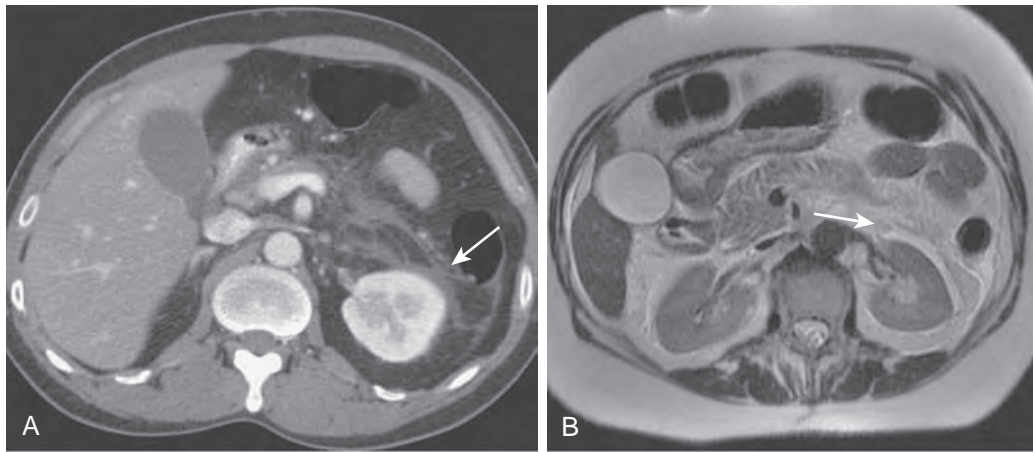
Inflammation of pancreatitis spreading from the pancreas to the left kidney by means of the splenorenal ligament: MRI and CT findings in the same patient. A. CT shows fluid inferior to the pancreatic tail that extends into the left perirenal space (arrow). B. Fat-suppressed, axial, T2-weighted MR image shows high signal intensity fluid (arrow) lateral to the left kidney in the perirenal space.
